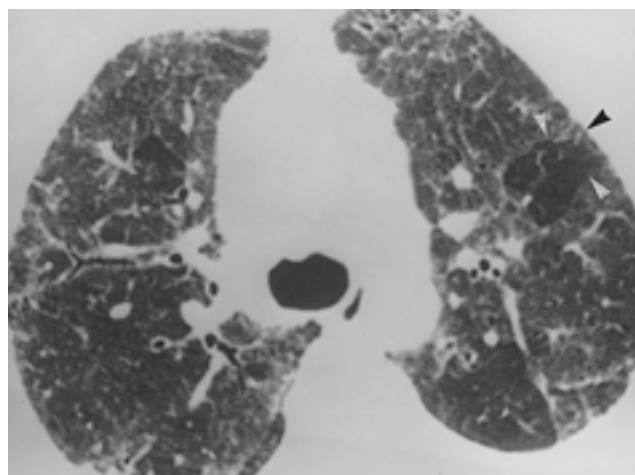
Forty two-year-old male patient with subacute hypersensitivity pneumonitis. HRCT scan shows ground glass attenuation involving both lungs. Sparsed areas of lobular low attenuation (arrow heads) in the area of ground glass opacity.
